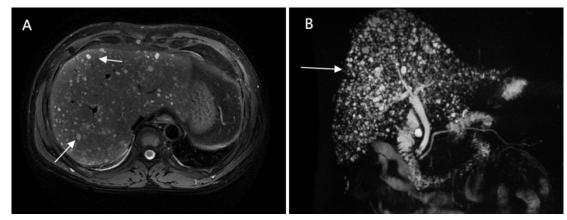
59-year-old male with Multiple biliary hamartomas (MBH) in liver (2024). Postoperative two-year follow-up MRI (3A) and MRCP (3B) showed no significant changes compared to the previous studies two years ago.
